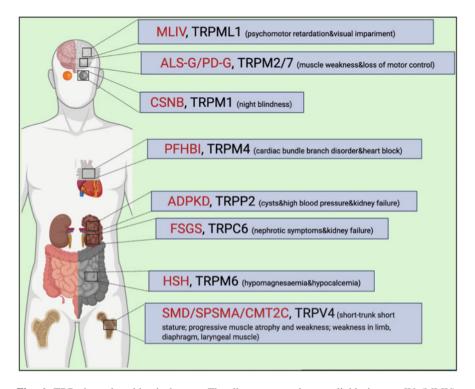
TRP channelopathies in human. The diseases, namely mucolipidosis type IV (MLIV), Guamanian amyotrophic lateral sclerosis/Guamanian parkinsonism dementia (ALS-G/PD-G), congenital stationary night blindness (CSNB), progressive familial heart block type I (PFHBI), autosomal dominant polycystin kidney disease (ADPKD), focal segmental glomerulosclerosis (FSGS), hypomagnesemia with secondary hypocalcemia (HSH), spondylometaphyseal dysplasia/ scapuloperoneal spinal muscular atrophy/Charcot–Marie–Tooth disease type 2C (SMD/SPSMA/CMT2C) are in red. The major organs affected by corresponding TRP(s) causing disorders are indicated as squares. The main clinical symptoms are described
